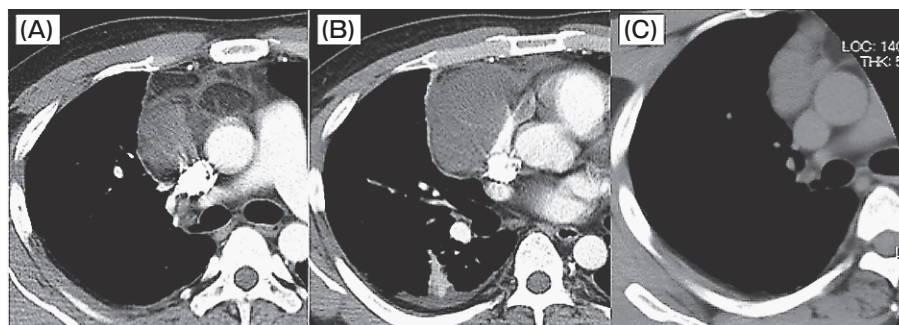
Enhanced chest CT shows a lobular cystic mass. A, B, Images at the hospitalization; C, There were no inflammatory findings around the mediastinal tumor 2 days prior to the hospitalization.
